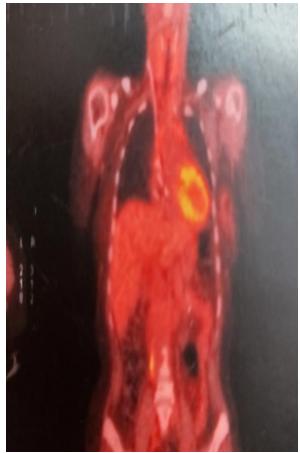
TEP scanner objectifying the thymic hyperplasia with SUV= 2,5
